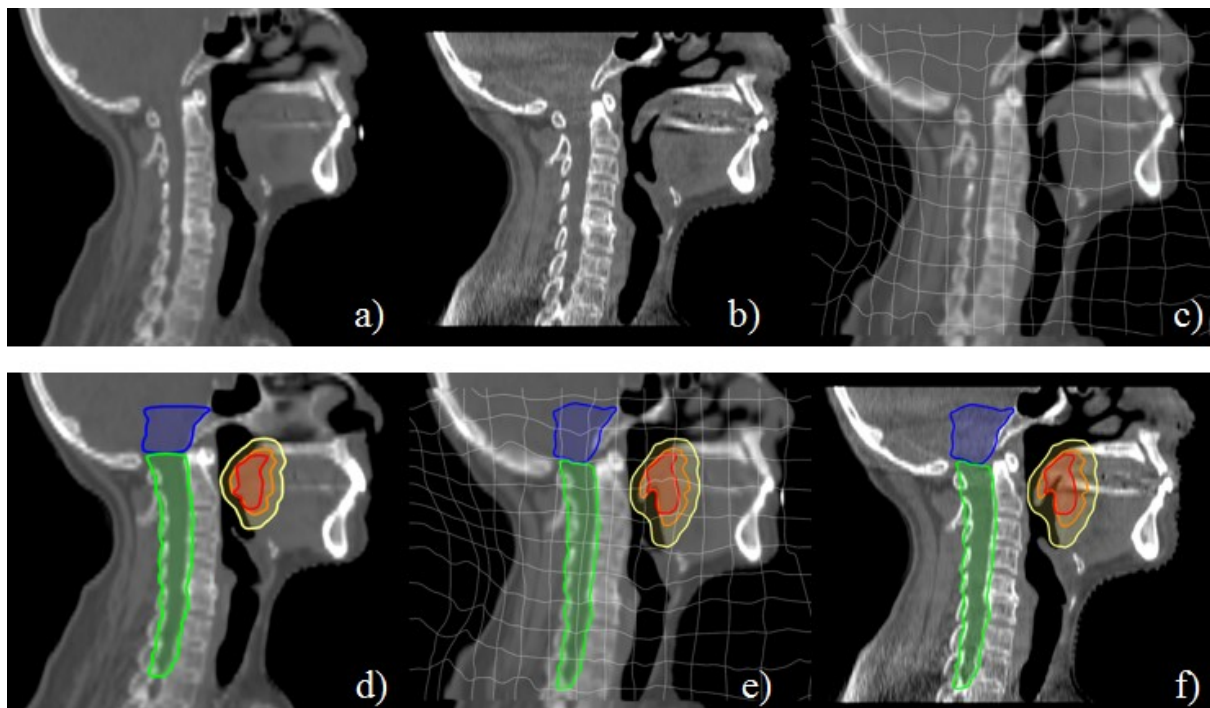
The contour propagation procedure. A planning computed tomography (pCT) scan (a) is matched with deformable image registration (DIR) to a cone beam CT (CBCT) scan (b) which generates a deformation vector field (DVF) (c). The original contours of the pCT (d) are deformed according to the DVF (e) and copied to the CBCT (f).
